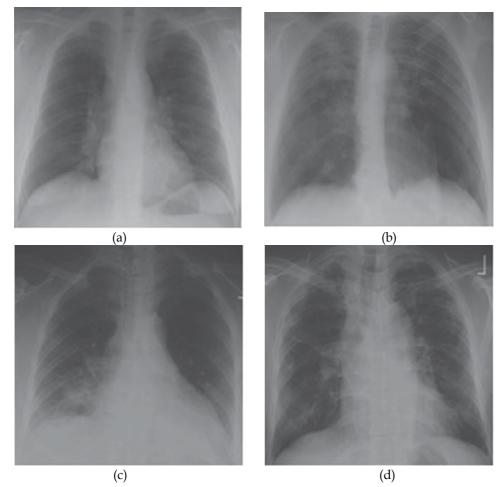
Radiographic stages of pulmonary sarcoidosis. (a) Stage 1: A 32-year-old female with hilar and right paratracheal lymphadenopathy. (b) Stage 2: A 61-year-old male with bilateral hilar adenopathy and parenchymal opacities. (c) Stage 3: A 54-year-old female with parenchymal opacities in the right lower lung. (d) Stage 4: A 51-year-old female with extensive increased interstitial markings.
